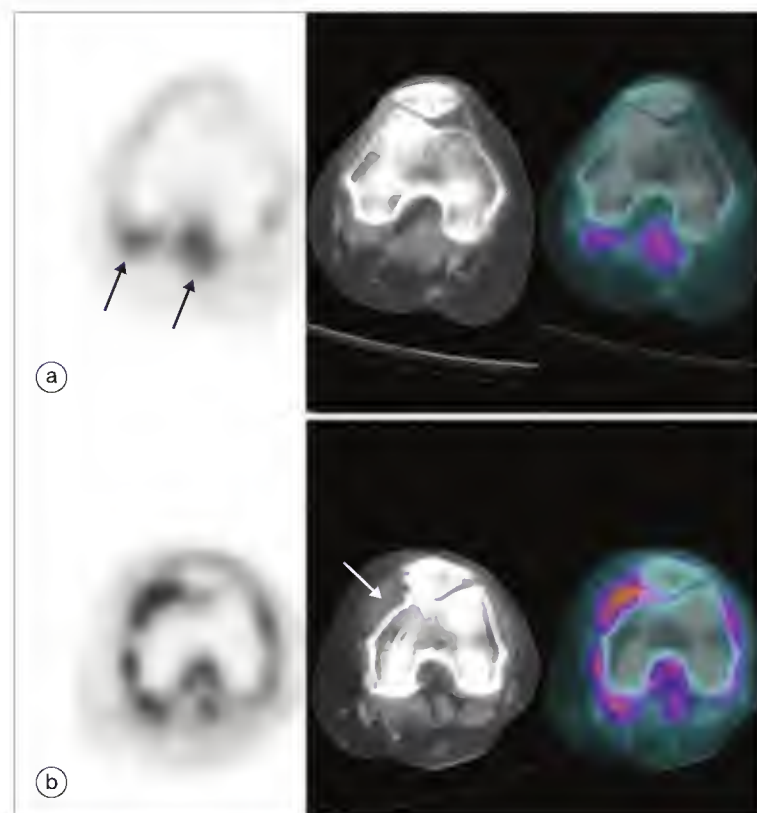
(a) ^{18}F -fluorodeoxyglucose positron emission tomographic (^{18}F -FDG-PET), computed tomographic (CT), and fused PET/CT transverse sections of a normal knee. The CT helps to identify foci of relative hyperactivity seen on PET images posterior to the internal condyle and intercondylar notch (black arrows) as physiologic muscle uptake. (b) ^{18}F -FDG-PET, CT, and fused PET/CT transverse sections of the knee of a patient with rheumatoid arthritis. The PET (left) and fusion (right) images show a vast hypermetabolic ringlike lesion surrounding the condyles, consistent with a synovitis. Note the thickening of the synovium recognizable on the CT image (white arrow).
